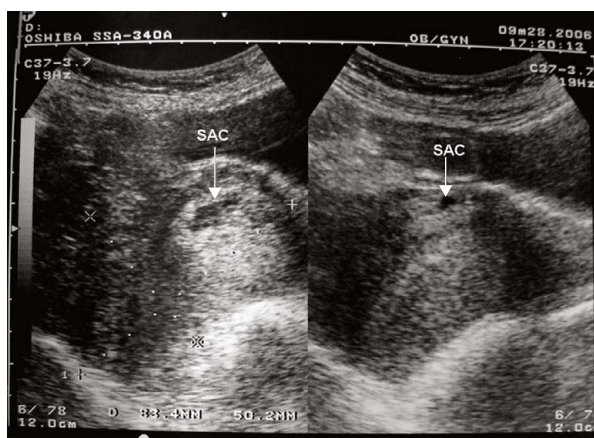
Transabdominal sonography showing implantation of the gestational sac (SAC) at the lower segment of the uterus (arrow). Note that the uterus is retroflexed at an acute angle.
